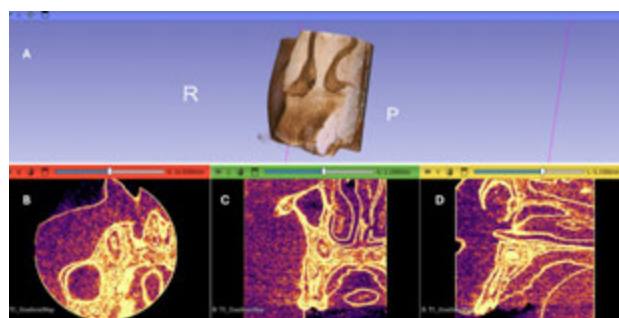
Multi-planar reconstruction of CBCT using automated gradient mapping
